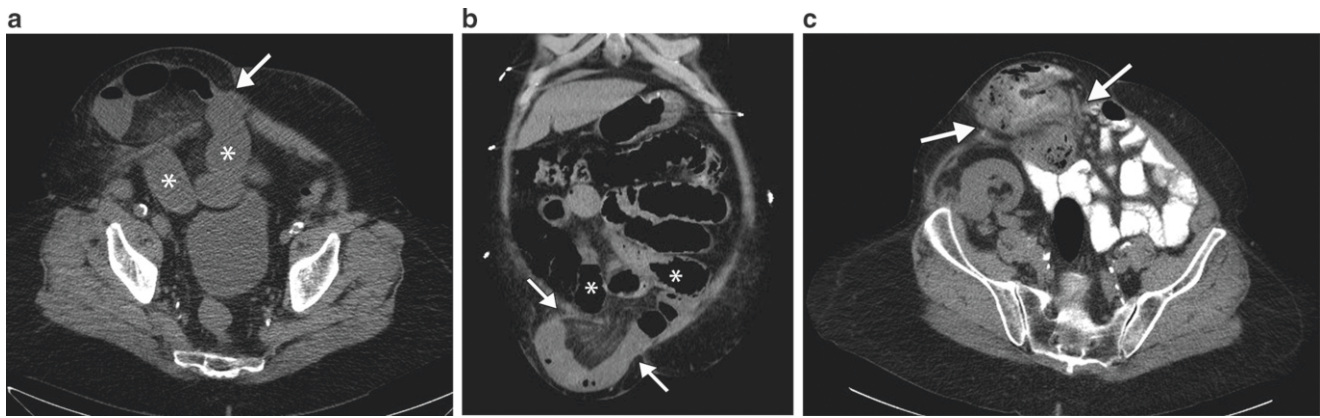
Incisional hernia. Axial CT shows dilated small bowel (*asterisk*) secondary to an incisional hernia (*arrow*). (a/b) Axial (a) and coronal (b) CT without oral contrast shows dilated small bowel loops
